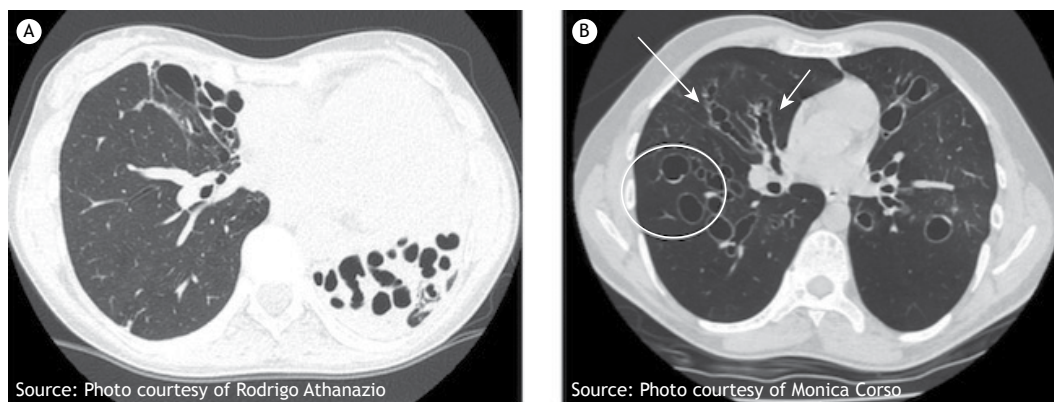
Chest HRCT scan. In A, cystic bronchiectasis in fibroatelectatic areas. In B, varicose bronchiectasis (arrows) and cystic bronchiectasis (circle). Note the loss of bronchial generations (loss of millimetric branching) and impaired visualization of bronchovascular markings, suggestive of air trapping (even during inhalation).
